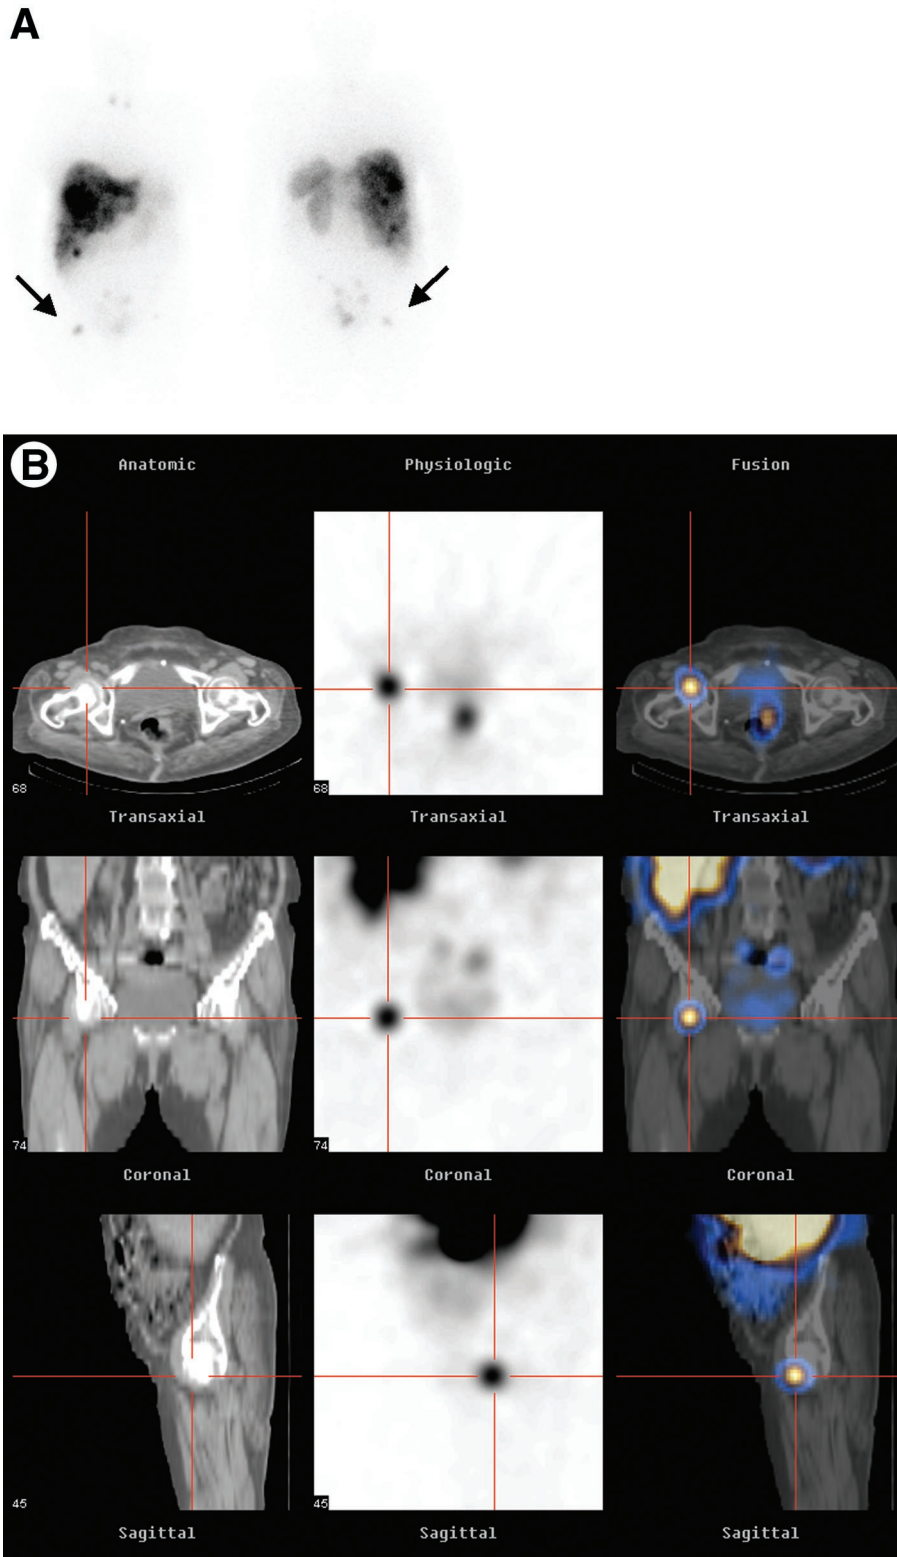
SPECT/CT for precise anatomic localization of abnormal In-111 Pentetreotide uptake in a patient referred for staging of carcinoid with multiple liver metastases at presentation. (A) Planar WB somatostatin receptor scintigraphy (anterior view–left, posterior–right) shows multiple foci of increased uptake in the liver. An additional focus of abnormal uptake is demonstrated in right pelvis (arrow). (B) In-111 pentetreotide SPECT/CT (CT–left ; SPECT–center; Fusion–right; transaxial–top row, coronal–mid row, and sagittal–bottom row) localizes the pelvic lesion to the right femoral head (red markers). The diagnosis of bone involvement led to a change in patient management.
